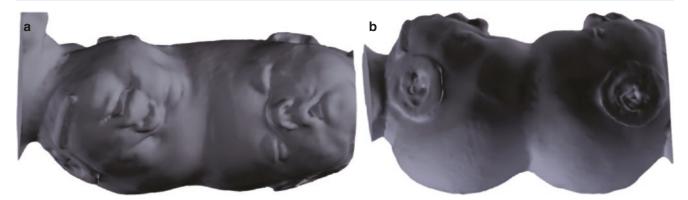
(a) Surface rendering of craniopagus twins based on magnetic resonance imaging. Note the orientation is at a slight lateral angle. (b) Shows the lateral view of the same surface rendering
